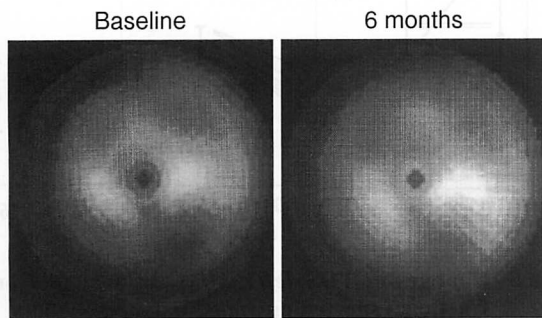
Iodine-123 BMIPP myocardial SPECT bull's-eye images before and 6 months after treatment in Responder 2
